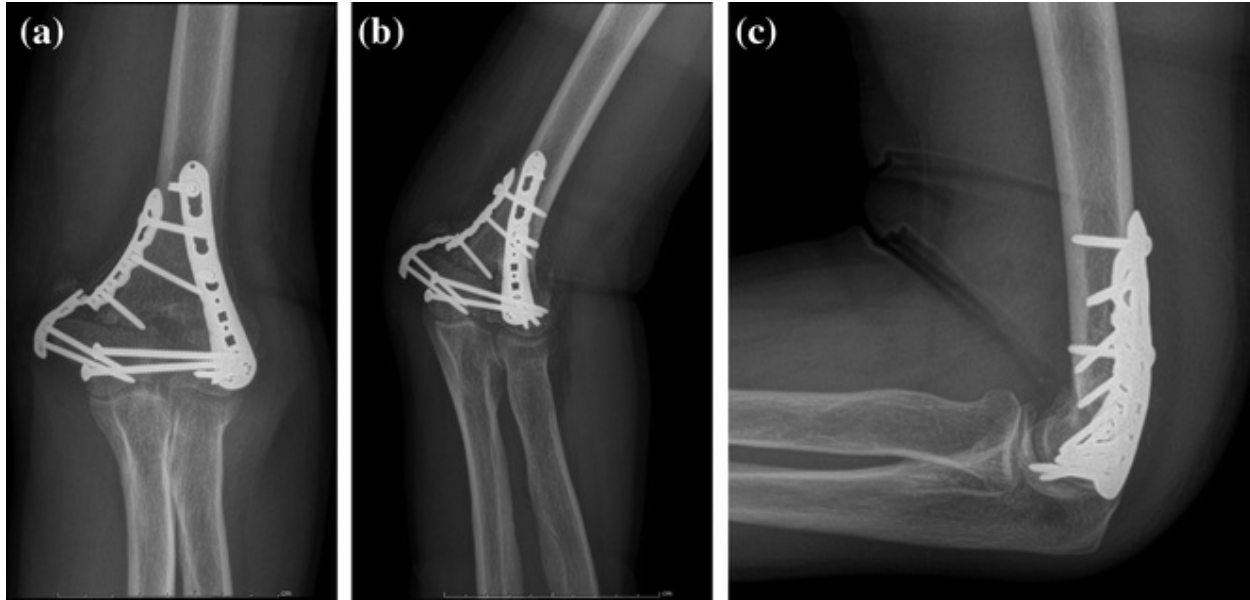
Anteroposterior (a), oblique (b), and lateral (c) radiographs show failure of medial plate, an indication that a nonunion is developing
